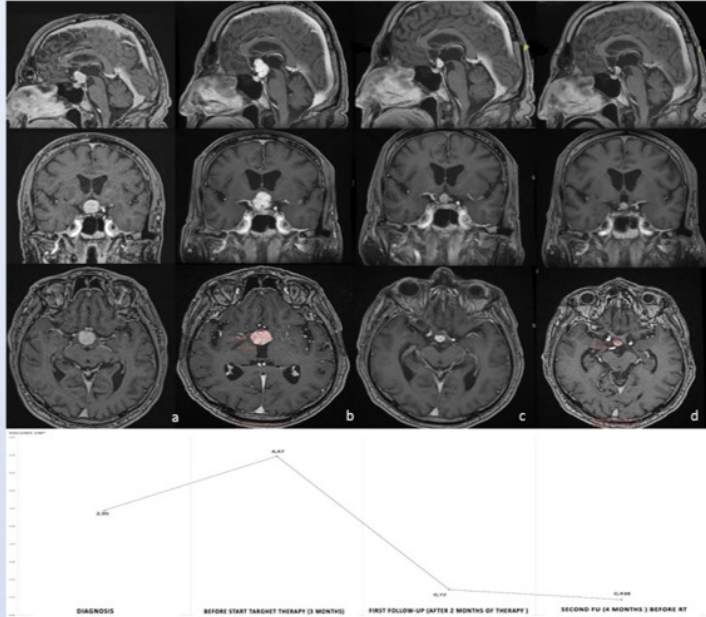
Post-gadolinium axial, coronal and sagittal T1WI MRI images showing result after Neoadjuvant treatment in 69 years-old man affected by newly diagnosed PCP (A) Postcontrast T1-weighted image shows large homogeneously enhanced intraventricular mass measuring 19 x 18.5 mm maximal axis and 2.945 cm3 volume. (B) Shows progression of the intraventricular tumor portion after trans-ventricular endoscopic biopsy (18% of tumor volume). Panels c and d show a dramatic reduction in volume at 2 months (C) and 4 months (D) after commencing combined BRAF/ MEK inhibitor treatment. Note complete resolution of the mass effect on suprasellar neurovascular structures and on Monro's foramen. Volume curve has been reported in the inferior part of figure. RT, radiotherapy.
